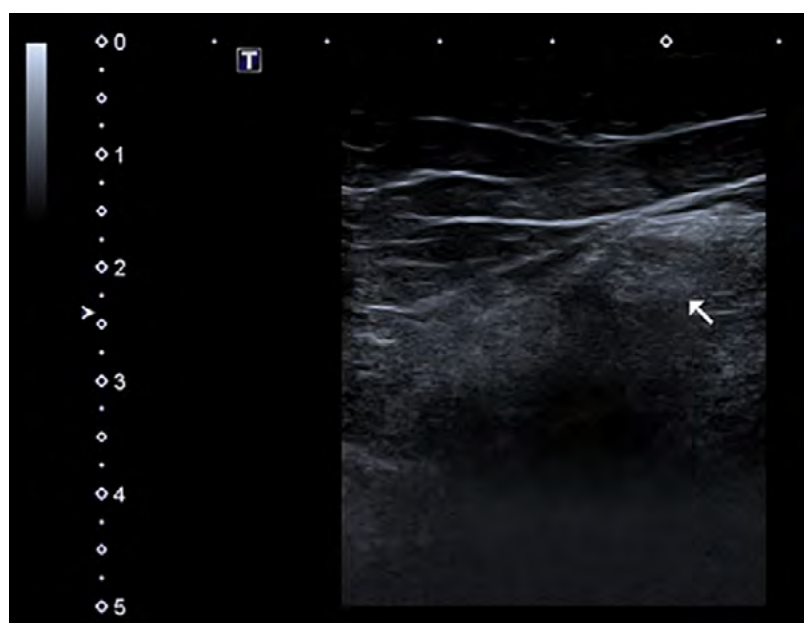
Ultrasound image of the patient's left popliteal sciatic nerve (white arrow)
